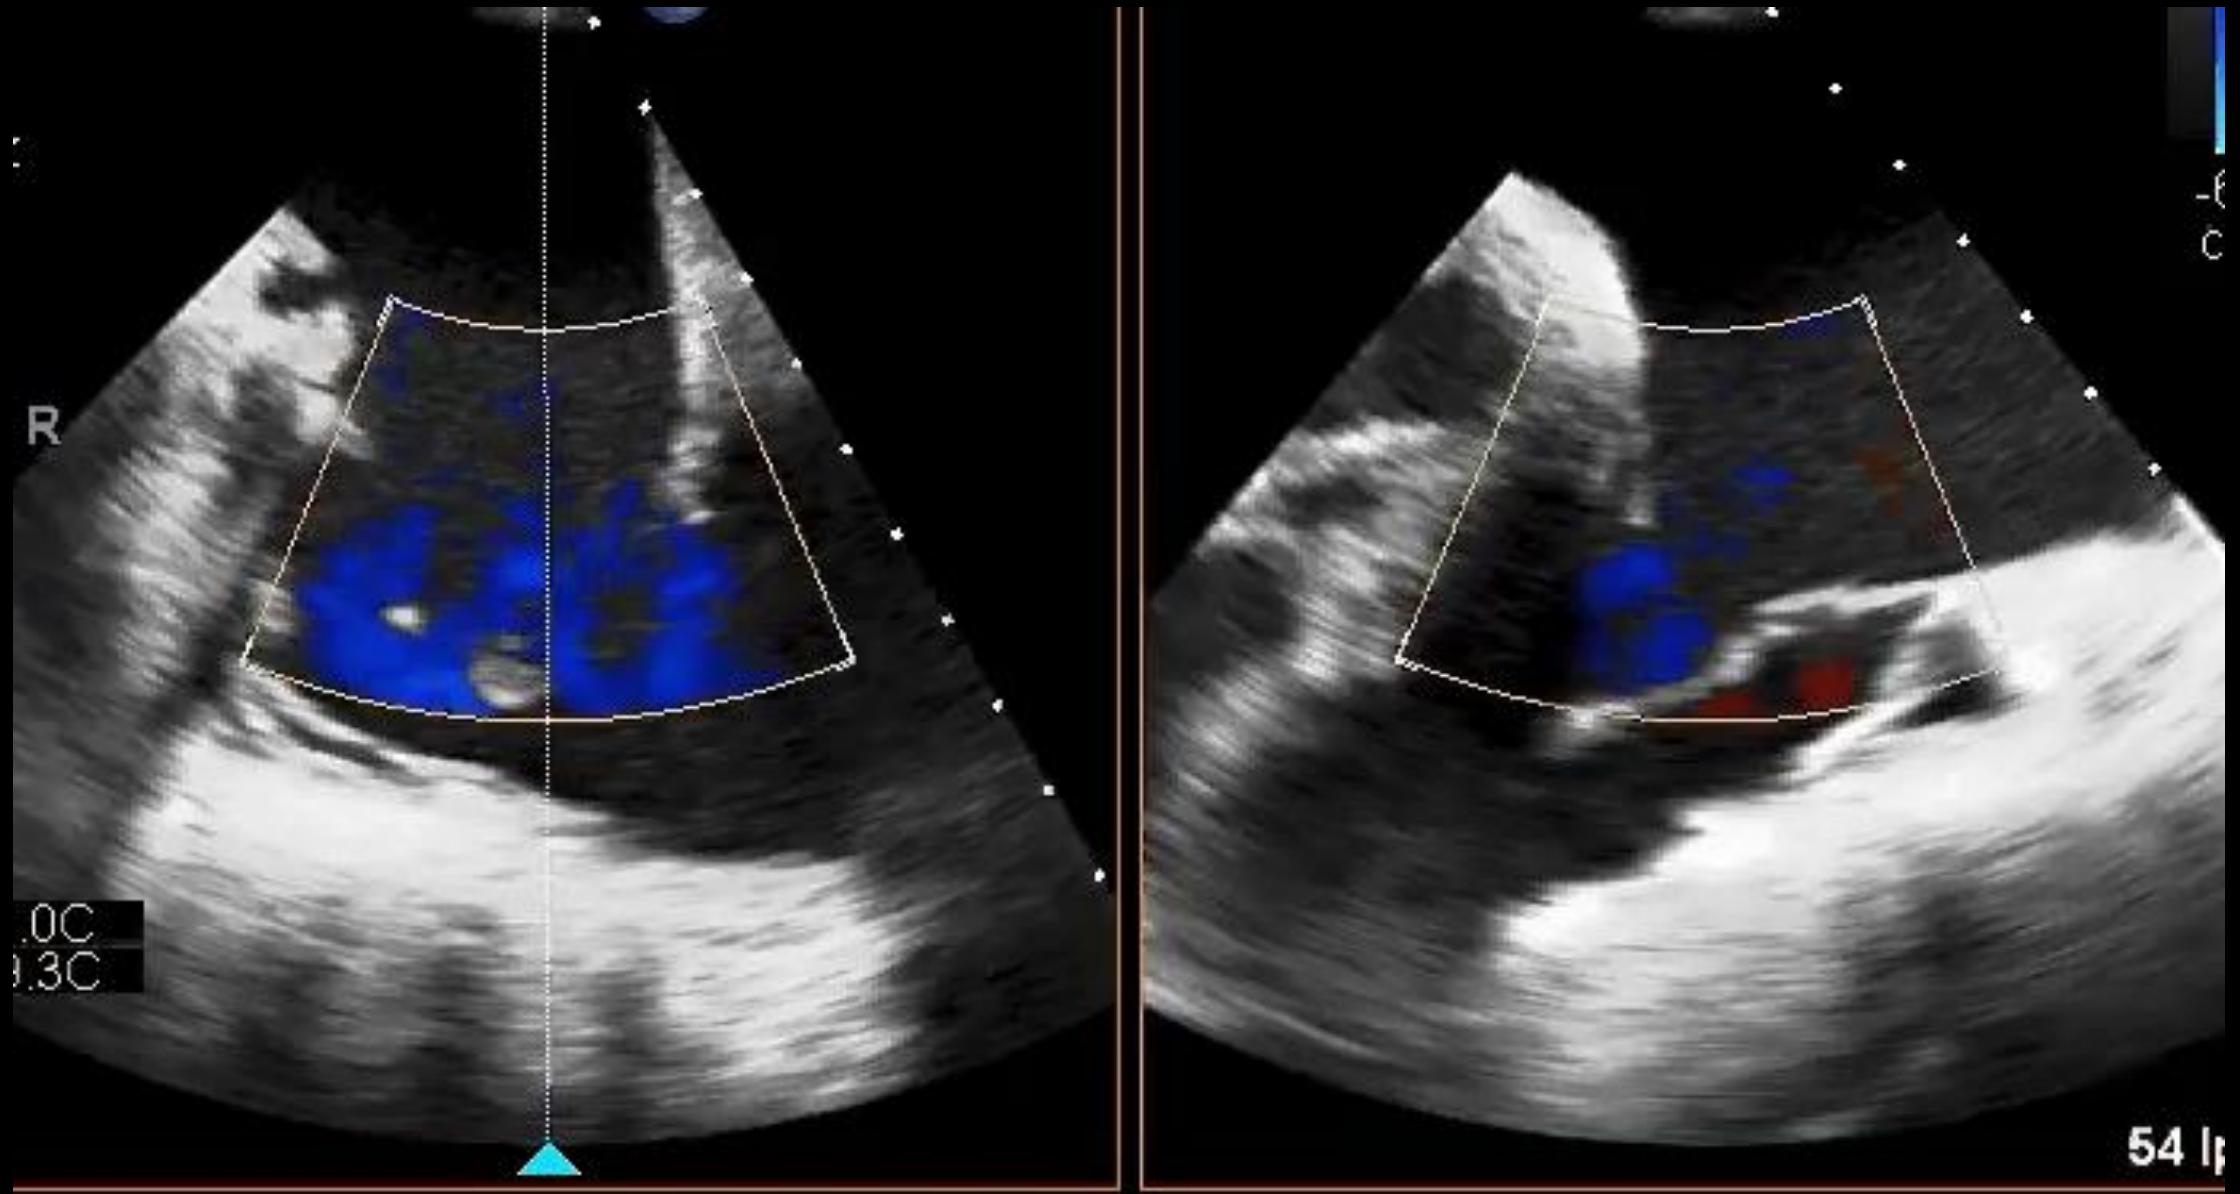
Anatomic, Interventional, and Echocardiographic Details
